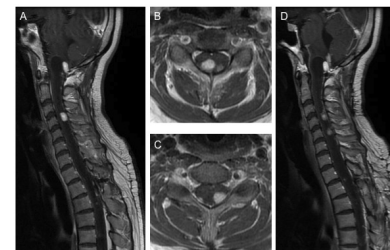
Radiological images of Case 3 associated with von Hippel-Lindau disease. Preoperative sagittal (A and D) and axial (B and C) T1-weighted MR imaging after gadolinium administration demonstrating homogeneously enhanced tumor of the dorsal of the spinal cord at the C4 level (B) and C5 level (C) with holocord syringomyelia.
